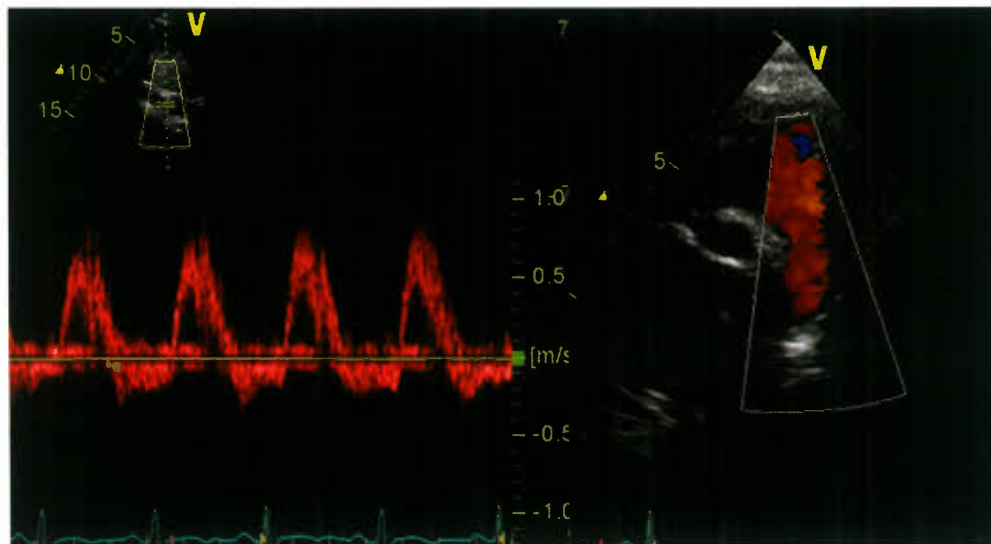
Patient with severe aortic regurgitation. Holodiastolic backflow in the abdominal aorta is shown on the pulsed Doppler tracing in the abdominal aorta. Color Doppler also shows the diastolic retrograde flow in the descending thoracic aorta.
